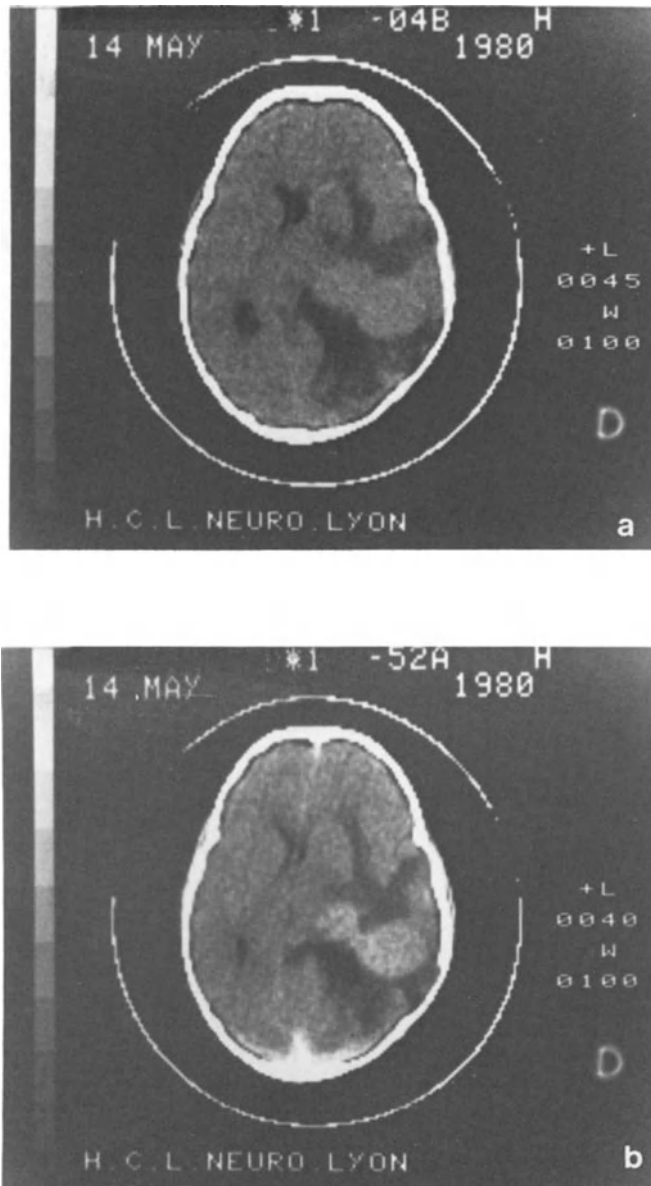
Right atrial meningioma. a) Pre-contrast CT. No hydrocephalus is present. Note the edema surrounding the tumor. b) Post-contrast CT
